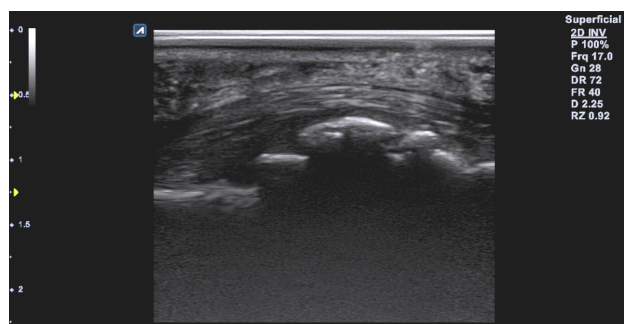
Ultrasound image, with 18 MHz on right 3rd PIP joint, longitudinal section, narrow joint space, with irregular surfaces, important osteophytes on both bone slopes. PIP: Proximal interphalangeal.
